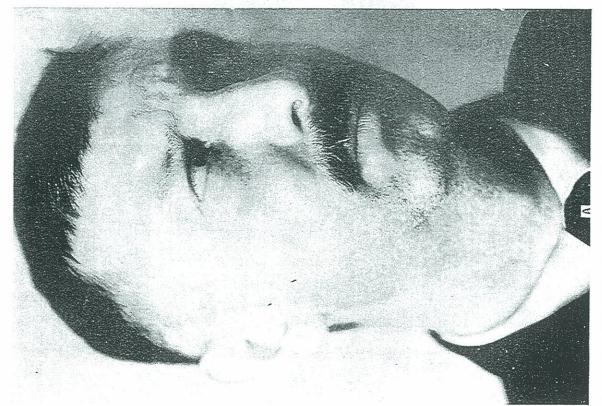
A, HUGE CYST BULGING THE CHEEK AND EYE. B, ROENTGENOGRAM OF ENORMOUS CYST CHAMBER FILLED WITH OPAQUE. THE MAXILLARY SINUS HAD BEEN EN-TIRELY OBLITERATED.
